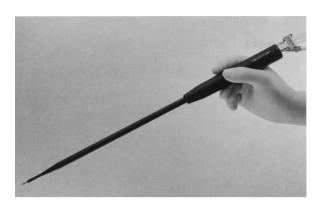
The ultrasonic dissector by Surgical Technology Group (Andover, Hampshire, UK) carries significant advantages for dissection of parenchymatous organs. Similar devices are available from ValleyLab/Pfizer and Söring
